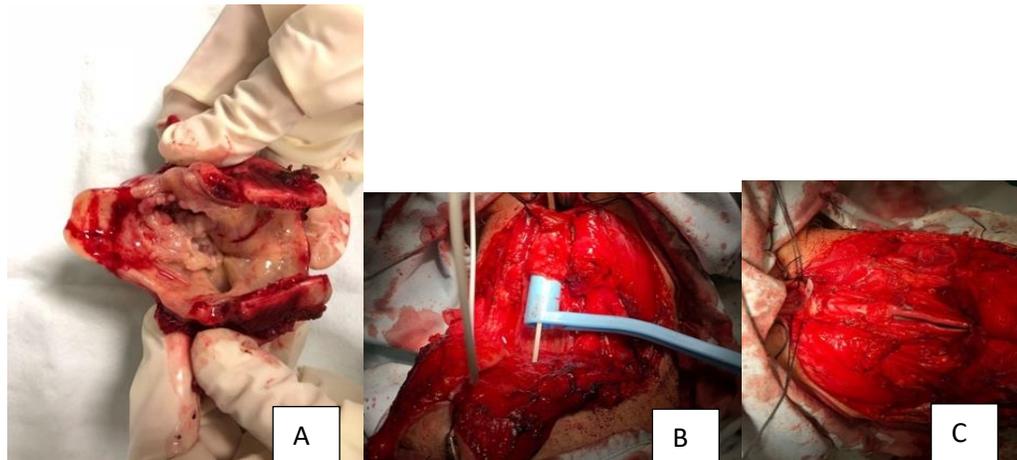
Total laryngectomy – A: resection piece; B: transesophageal puncture and fixing the voice prosthesis; C: fixing the stoma and checking the voice prosthesis
